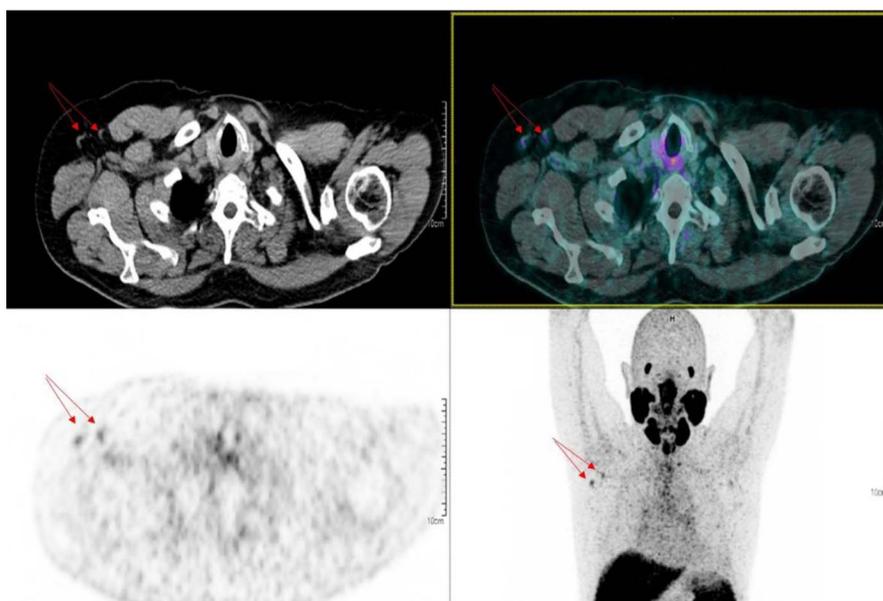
A 74 year-old man underwent a ^{68}Ga -PSMA-11 PET/CT for rising PSA after radical treatment. Two right axillary LNs (red arrows) with higher uptake than the mediastinum were detected. The man received the first and second doses of the ChAdOx1-S (AstraZeneca) vaccine, respectively, 80 and 19 days before undergoing this PET/CT.
